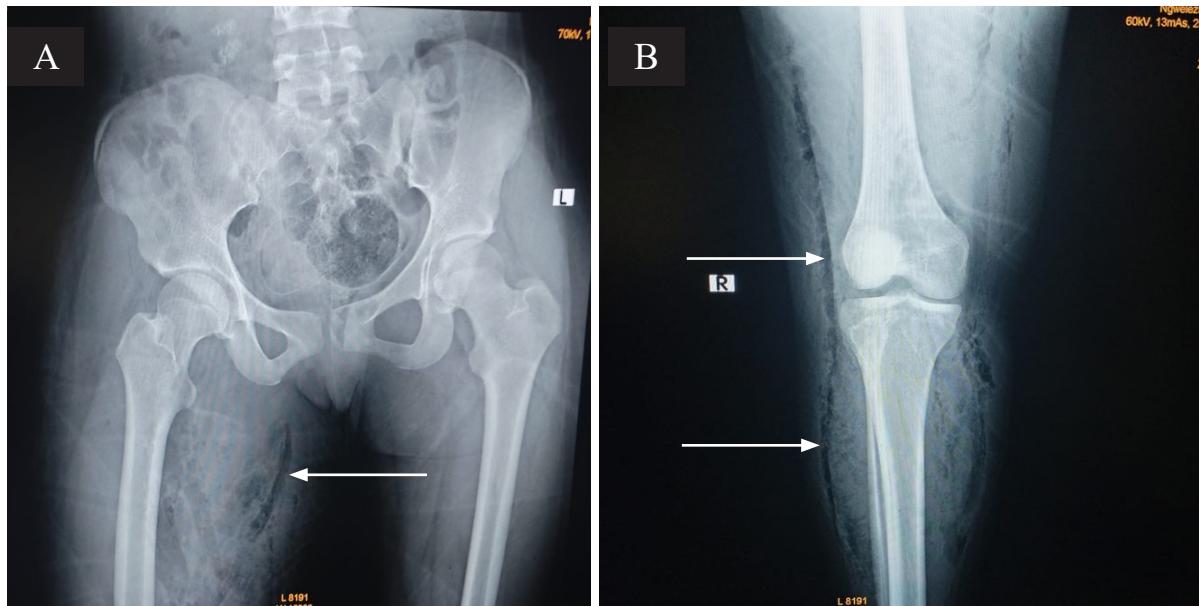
1A – X-ray of the pelvis showing air in the medial thigh, see white arrow; 1B – X-ray of the right knee with white arrows indicating significant subcutaneous emphysema
